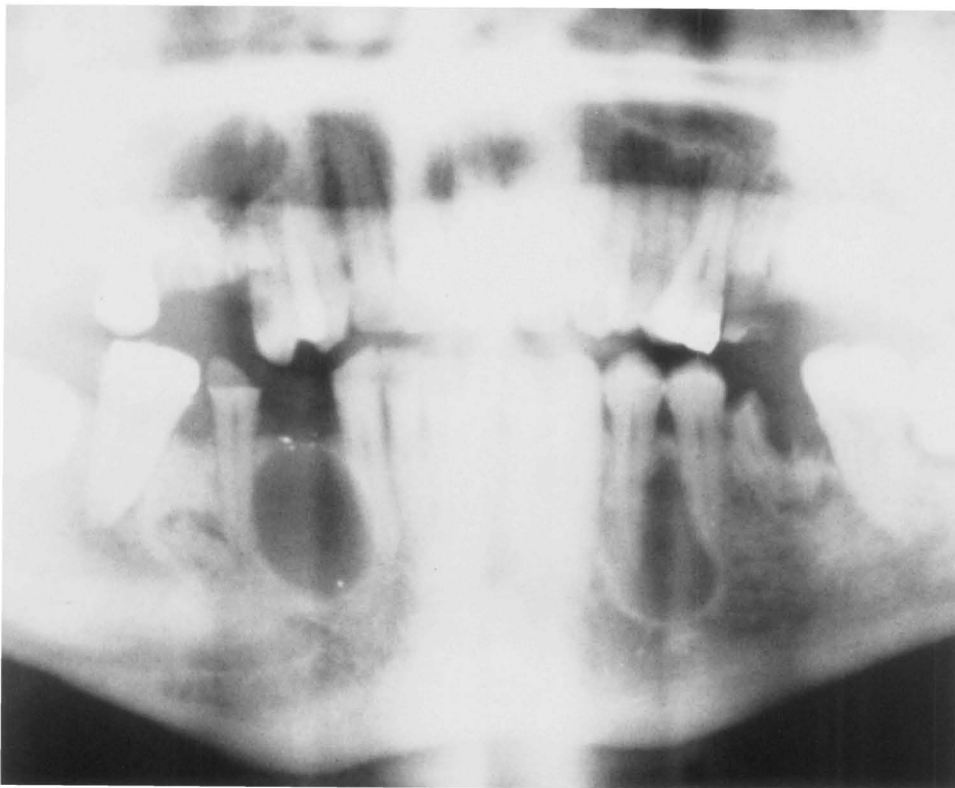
Part of a panoral radiograph, demonstrating an odontogenic keratocyst appearing as a lateral periodontal cyst on the left side of the mandible and as a residual cyst on the right, in a patient with multiple cysts.
